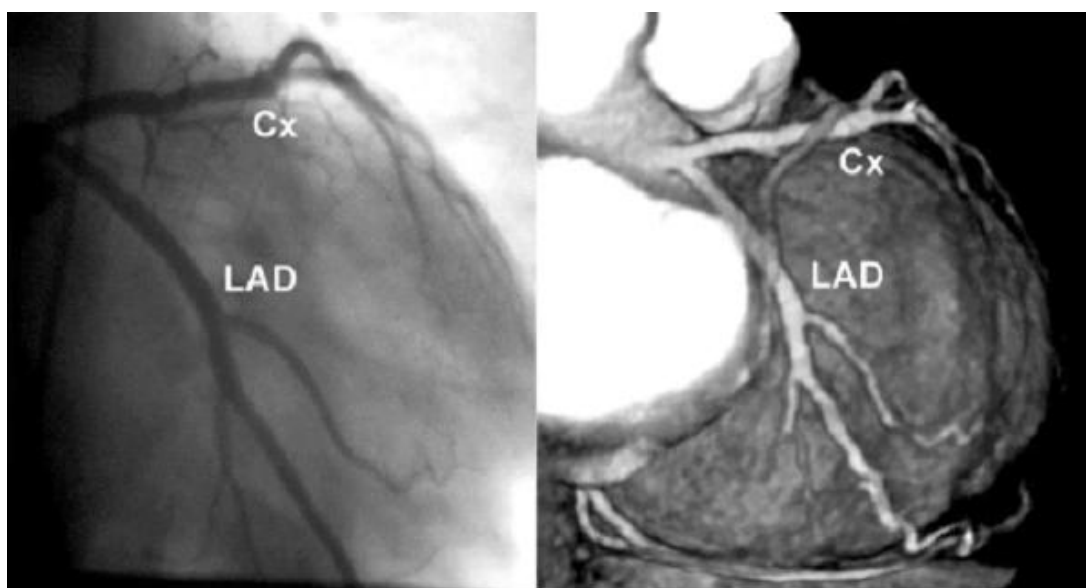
Comparison of conventional angiography and volume-rendering of a CTA acquired with a 4-rows CT. The coronaries are well delineated, but small branches are not visible in the CTA. Scanners with 64 or more rows allow to further improve the quality of the resulting CTA, providing a quality which is comparable to that of conventional angiography. Image reprinted from [266] with permission granted by the copyright holder (Radiological Society of North America) and by the author.
